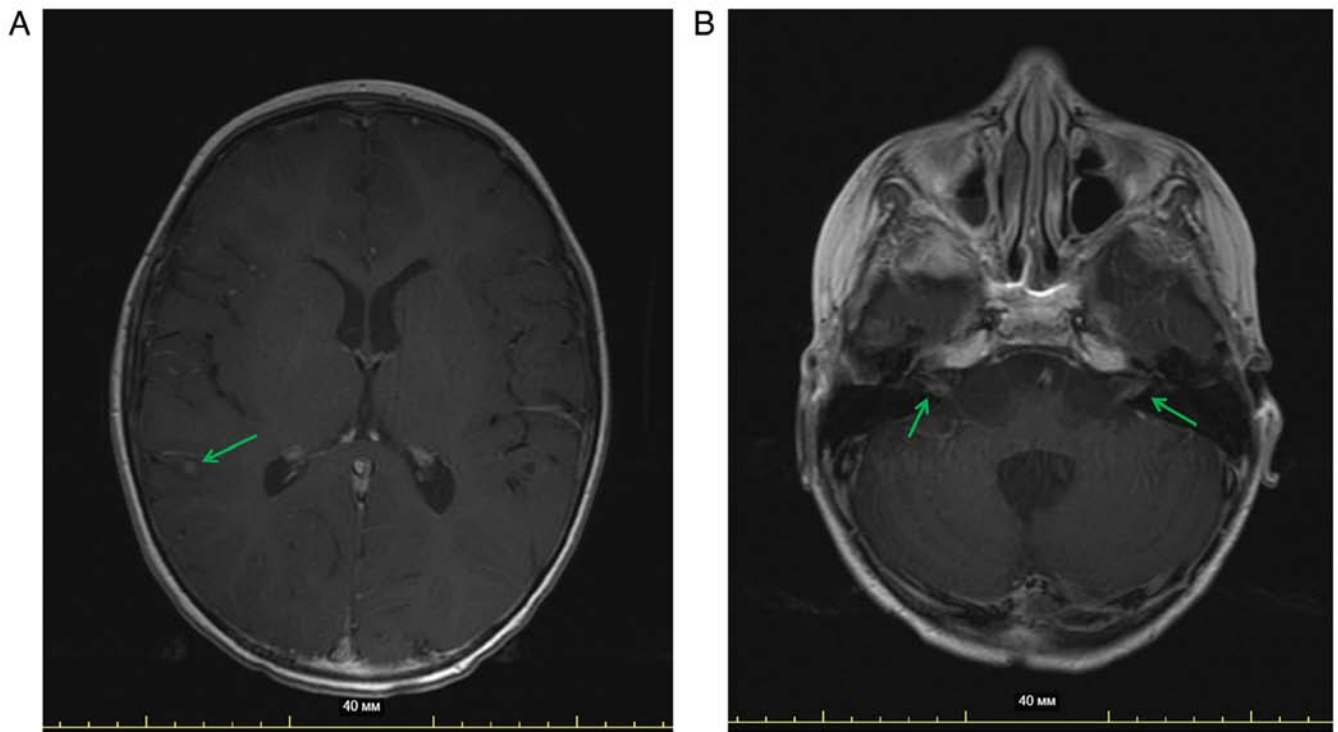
Central nervous system MRI of the patient after the 6th cycle of maintenance therapy with temozolomide indicated disease progression (new leptomeningeal metastases in the brain). Brain MRI (Ax T1 SE + C) indicated new lesions of contrast enhancement in (A) the region of the right temporal lobe and (B) membranes of the vestibulocochlear nerves (green arrows; scale bars, 40 mm).
